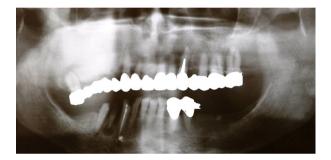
Pre-remodelling panoramic X-ray.
